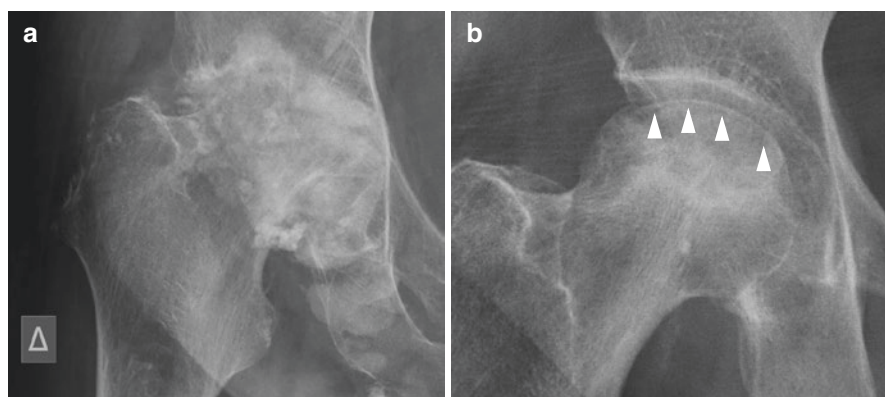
Osteonecrosis radiographic images
